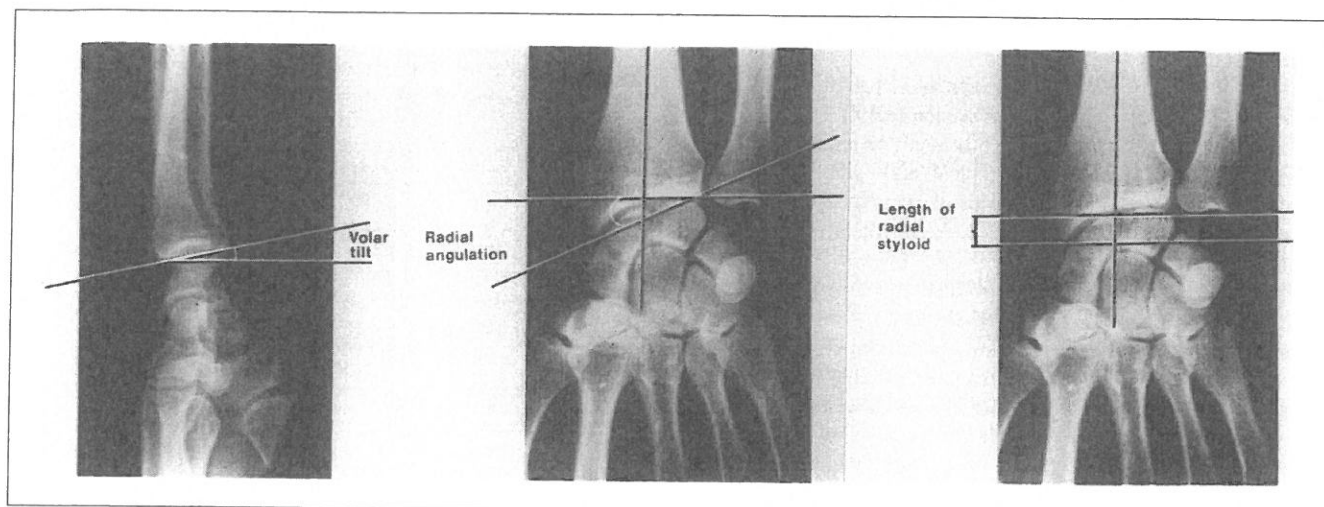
Radiographs of a normal wrist demonstrating the measurement of volar tilt (left), radial angulation (center) and length of radial styloid distal to ulna.
